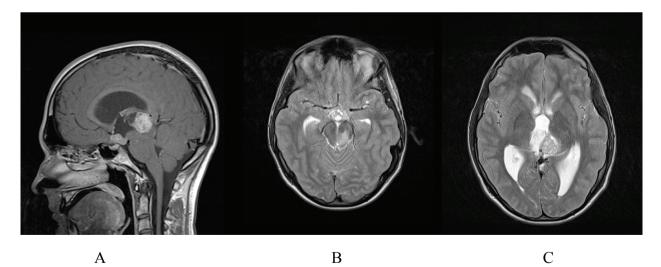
Sagittal T1 sequence of the brain magnetic resonance imaging (MRI) showing bifocal tumor lesions in suprasellar and pineal regions (A); axial T2 brain MRI showing predominantly solid sellar region lesion (B); axial T2 brain MRI showing pineal region lesion with cystic and solid components and ventricular dilatation (C).
